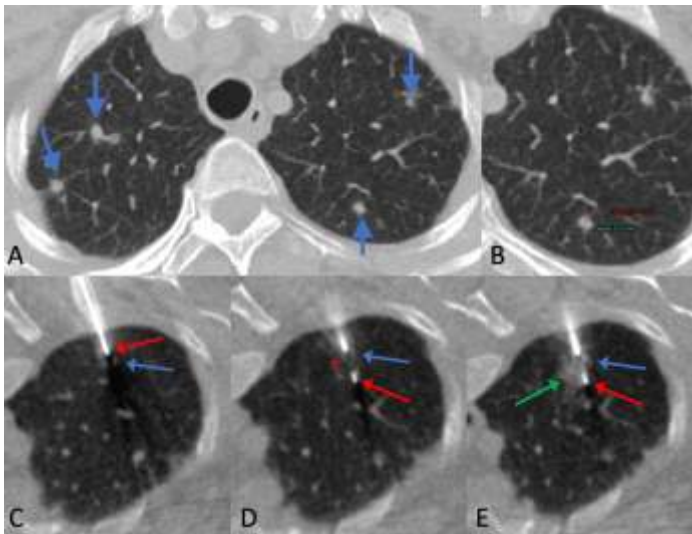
Granulomatous disease. 48 years old woman diagnosed recently to have buccal cancer. PET/CT showed multiple lung nodules (blue arrows in A). A 3.5 x 3.6 mm nodule in the left upper lobe was identified (B) so that the biopsy could be done in the prone position. The blue arrow in images C, D and E shows the nodule, while the red arrow shows the tip of the cannula in C and the tip of the deployed gun in D and E. The green arrow in E shows the small peri-nodular hemorrhage.
